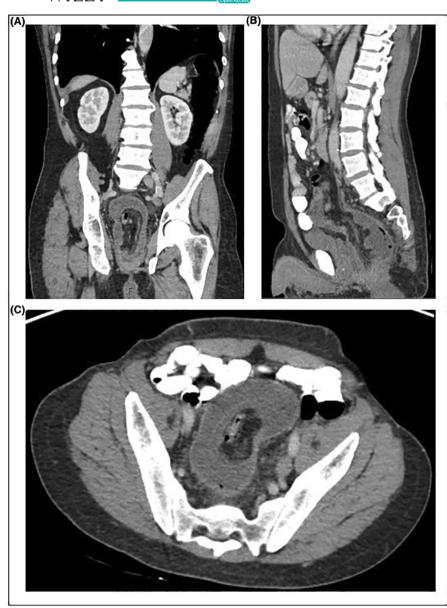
CT scan demonstrating intussusception (A) Coronal View, (B) Sagittal view, (C) Axial View.
